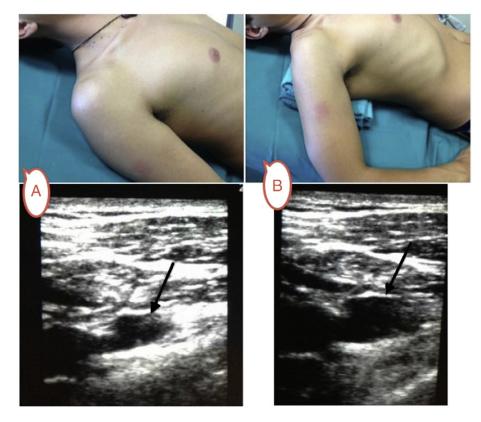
Effect of forward position of the shoulder and 90° arm abduction on AV diameter. A, Neutral position of the arm and the shoulder; transversal ultrasound scan of the AV (black arrow). B, Forward position of the shoulder and 90° abduction of the arm determining increase in AV diameter (black arrow).
